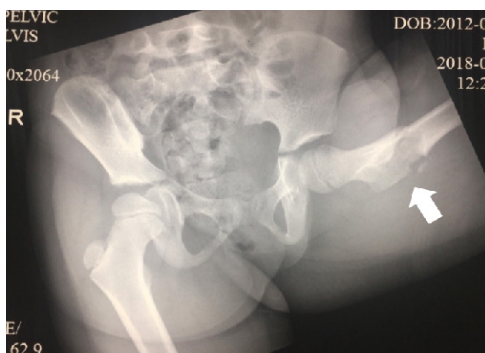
Posteroanterior pelvic X-ray of the patient at day 3 of trauma. The arrow shows comminuted intertrochanteric fracture of left femur
